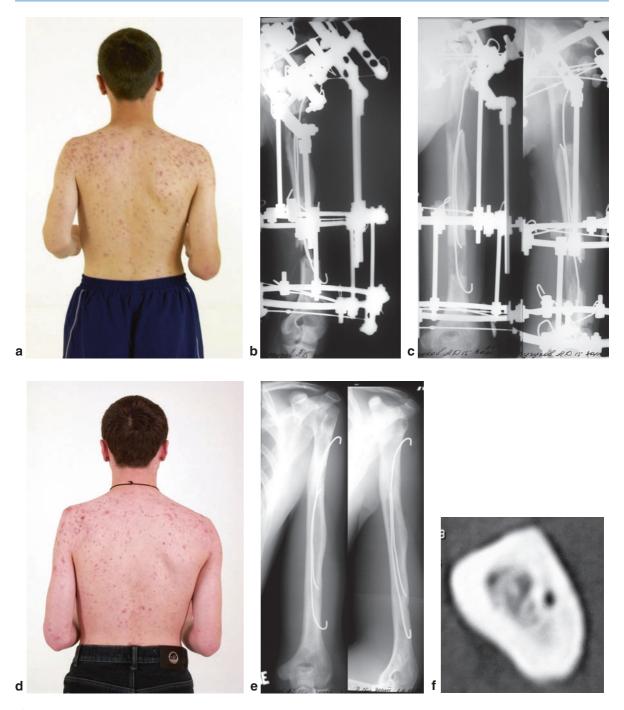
An 18-year-old male with sequelae of hematogenous osteomyelitis of the *left humerus* before surgery (a). External fixator and sliding flexible intramedullary nailing (FIN); (b) X-ray taken after 21 days of lengthening; (c) X-ray taken at the end of the fixation period; (d) 1 year later, 80 mm
